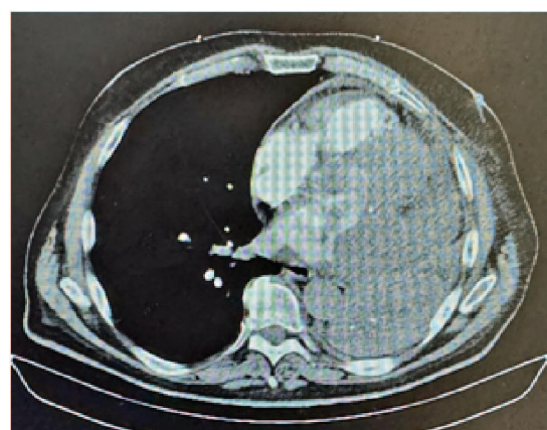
Computed tomography showing a pulmonary mass infiltrating the left main bronchus, left atrium, pulmonary truncus, and heart pericardium.
